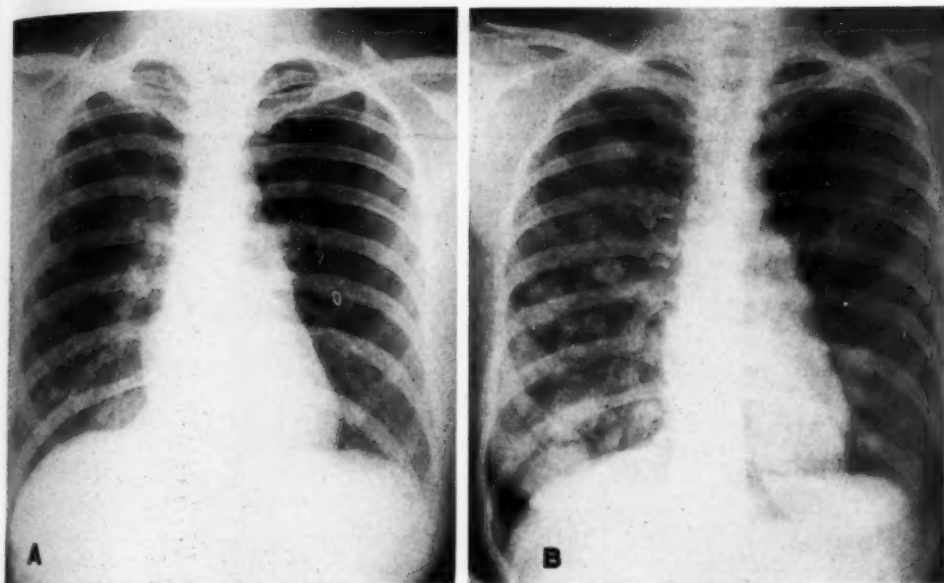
Case 2. A. Jan. 10, 1945. Two small pulmonary metastases are present in the right lung. One is projected on the lower margin of the anterior part of the right sixth rib; the other is projected onto the anterior part of the right second rib. This roentgenogram was made ten years after the appearance of a pseudo-adenomatous basal-cell carcinoma in the left parotid gland. No pulmonary symptoms.
